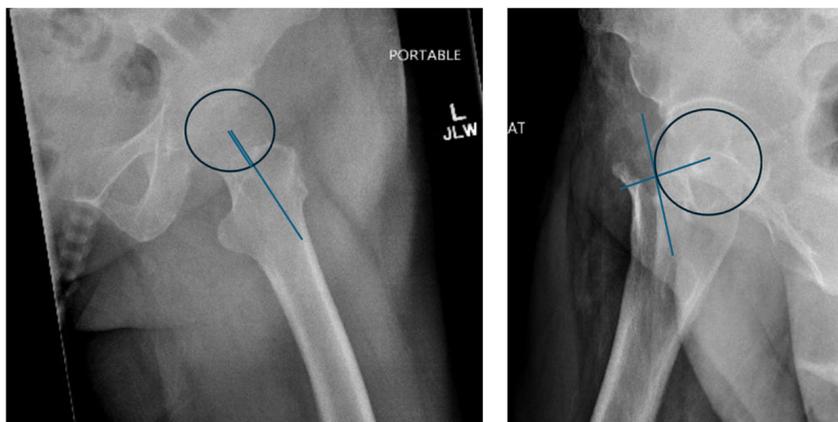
Two patients who both presented with neck of femur fracture who on the AP radiograph would have been labeled at Garden 1. However, on the lateral views show below one patient has essentially no posterior tilt while the other has almost 90 degrees. The patient with little or no tilt remains a candidate for in situ fixation while the patient with significant tilt requires replacements
